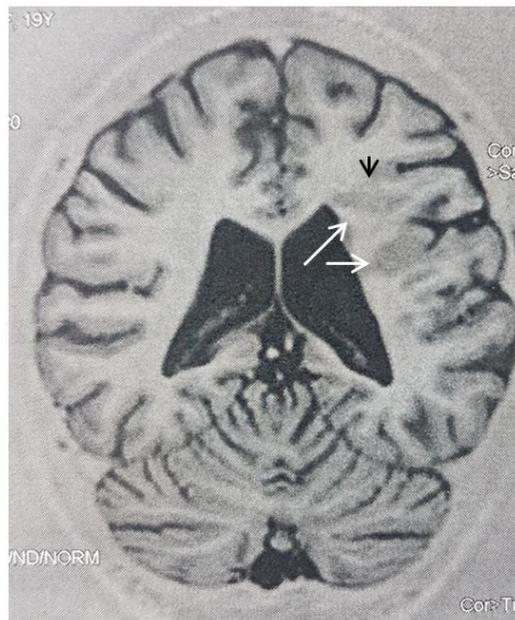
Cerebral MRI: T1-weighted coronal slice showing the same lesion in inverted signal (white arrows). White-gray matter junction with blurred boundaries (black arrow)
